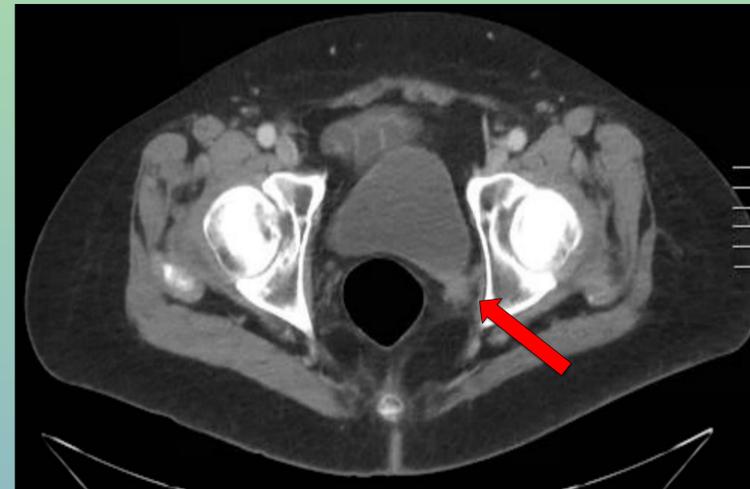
(above): CT AP showing pelvic sidewall mass (prostate cancer involvement) unchanged from prior.
